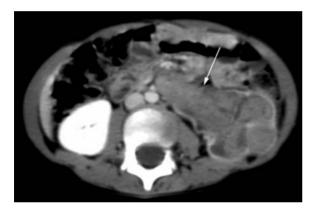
Botryoid form of Wilms' tumor in a 4-year-old girl. Enhanced CT scan shows intrapelvic extension (*arrow*)
